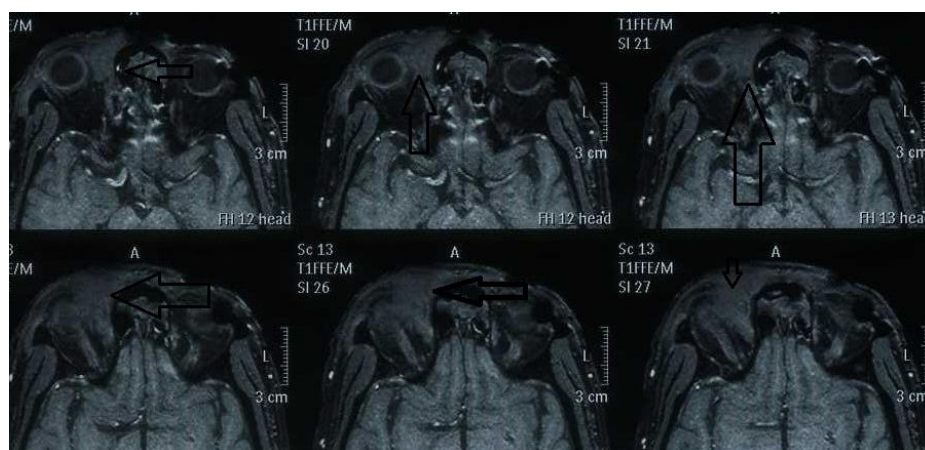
Axial T1 weighted post contrast MRI image showing mildly enhancing hypointense lesion in right forehead region reaching upto medial canthus of right eye (arrows)
